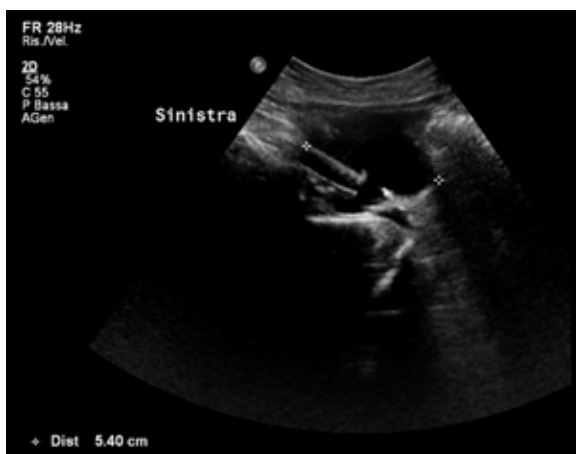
Ultrasound (US) image (oblique para-sagittal plane) showing an anechoic, eccentric, large sac clearly communicating with the lumen of the grafted left external iliac artery. The finding is consistent with a para-anastomotic pseudoaneurysm.
